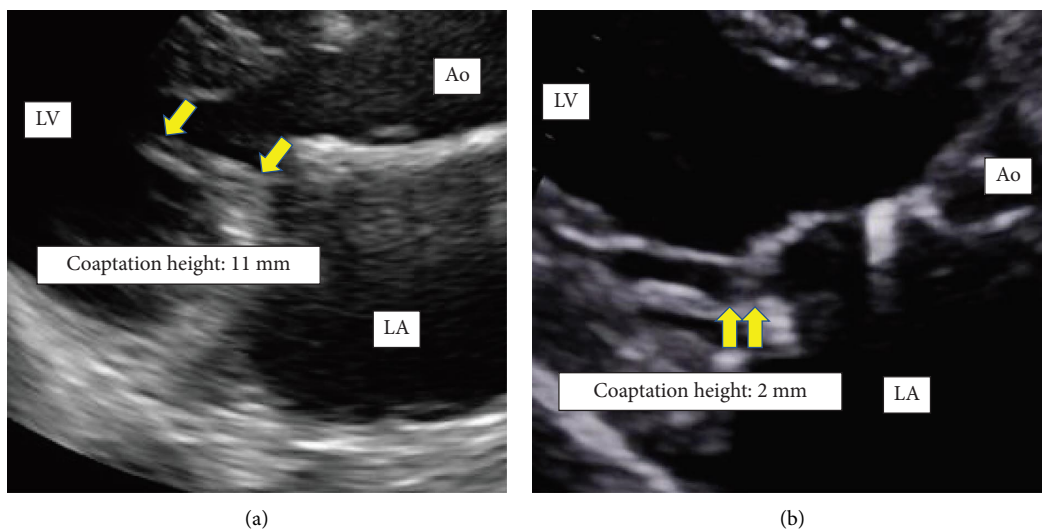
Echocardiographic findings on postoperative coaptation height in patients without (a) and with (b) recurrent mitral regurgitation after mitral annuloplasty for atrial functional mitral regurgitation. The yellow arrows show the coaptation range. LV; left ventricle, Ao; aorta, LA; left atrium.
